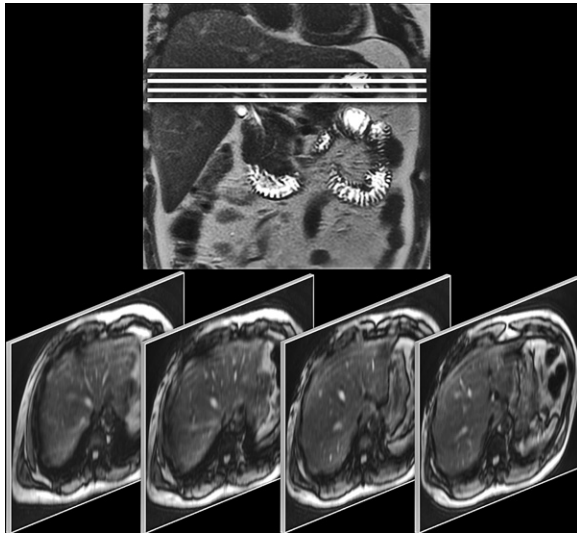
MR elastography section positioning. Top: Coronal T2-weighted MR image shows the sites (four lines) where the four MR elastography magnitude image sections at the bottom were obtained. Bottom: Magnitude image sections include the largest portion of the liver, with the liver dome and inferior aspect of the liver excluded.
